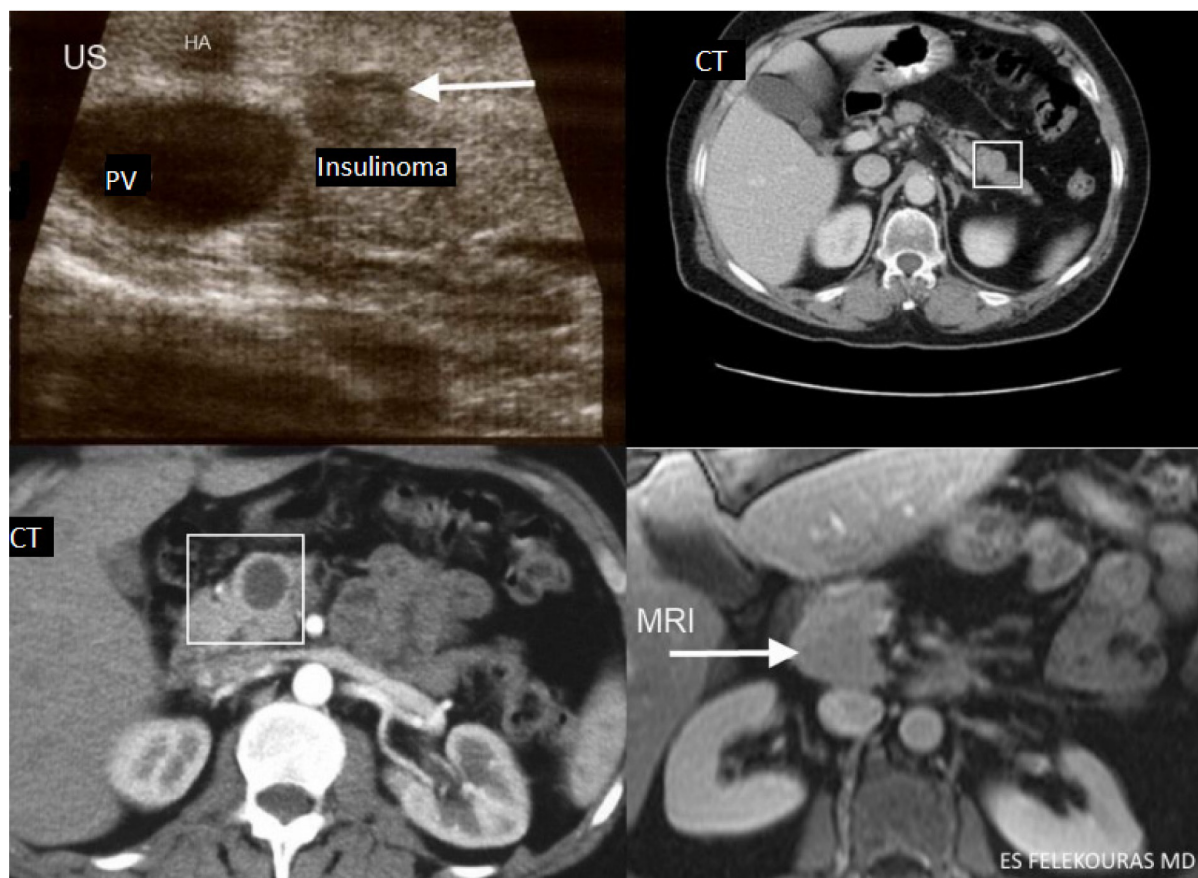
U/S, CT and MRI appearance of insulinoma. Preoperative imaging confirmation and localization are of great importance in the context of surgical planning.
